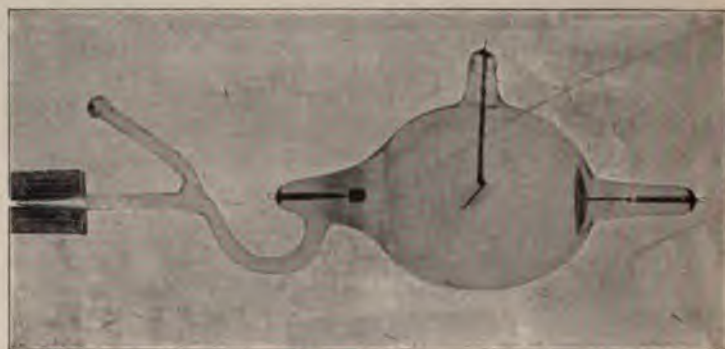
Adjustable X-Ray Tube.
